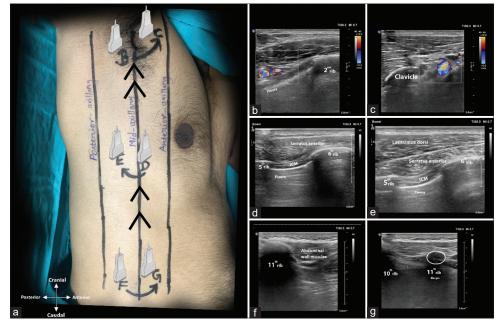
Sequential coronal sonogram from caudal to cephalad for rib counting (same subject). (a) Image of the lateral chest wall and different transducer positions. (f and g) The 11th rib disappears when the transducer is moved anteriorly. (d and e) Serratus plane between latissimus dorsi and serratus anterior visible on moving transducer posteriorly. (b) 2nd rib with adjoining neurovascular bundle seen. (c) Scanning beyond the 2nd rib, the lateral margin of the clavicle is visible
